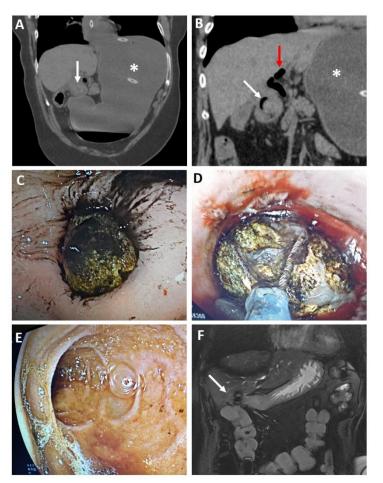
A – Frontal plane abdominal computed tomography scan showing a dilated stomach (asterisk) and the gallstone stuck in the duodenal bulb (white arrow); B – frontal plane abdominal computed tomography scan showing dilated bile ducts with pneumobilia (red arrow), dilated stomach (asterisk), and the gallstone stuck in the duodenal bulb (white arrow); C – endoscopic picture of gallstone stuck in the pylorus; D – endoscopic picture of gallstone captured in the Dormia basket; E – endoscopic picture of patent duodenal bulb after the gallstone removal; F – frontal plane magnetic resonance imaging scan of the patient's abdomen showing the bilioduodenal fistula (white arrow)
